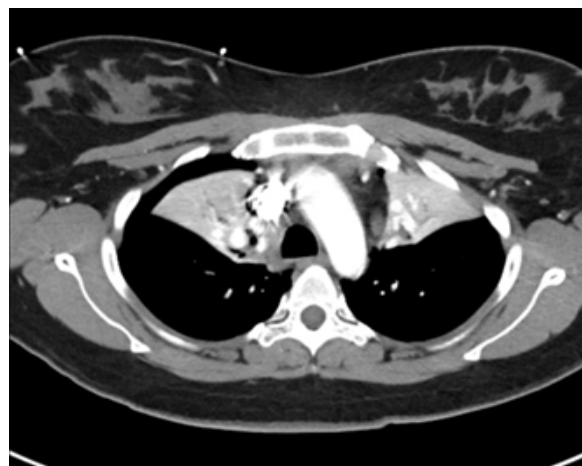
CT chest showing bilateral upper lobe collapse with bilateral pneumothoraces.
